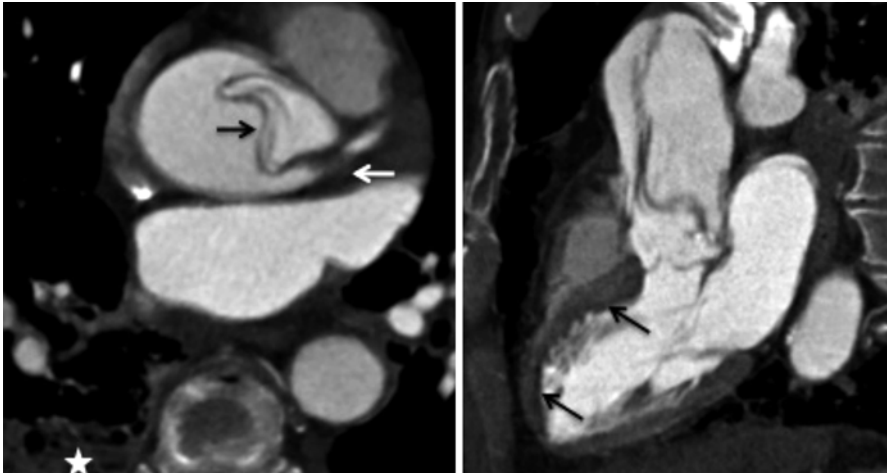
Axial CT images from a 55-year old female with complex Type A dissection. *Left panel* shows the flap in the aortic root (*black arrow*) with thrombus in the left main coronary artery (*white arrow*). *Right panel* is a left ventricular outflow tract view demonstrating the extent of the flap as well as the perfusion defect in the anterior wall of the left ventricle (*black arrows*) due to acute myocardial ischemia. *White star* corresponds to small right pleural effusion with basal consolidation
